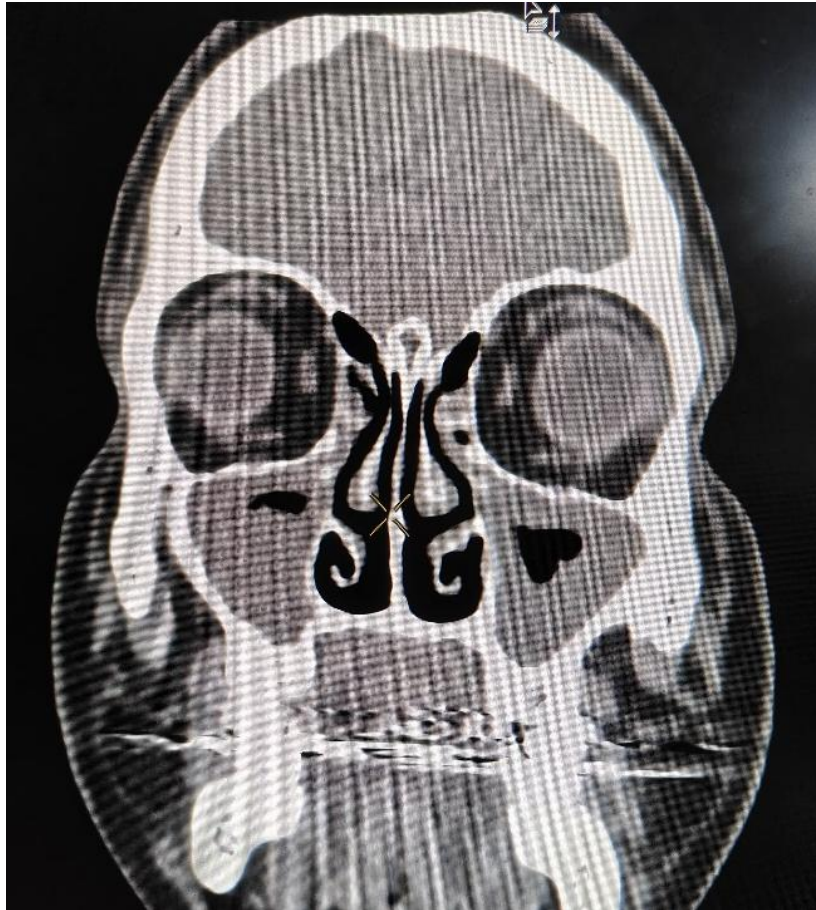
Axial view CT PNS showing presence of septa within
